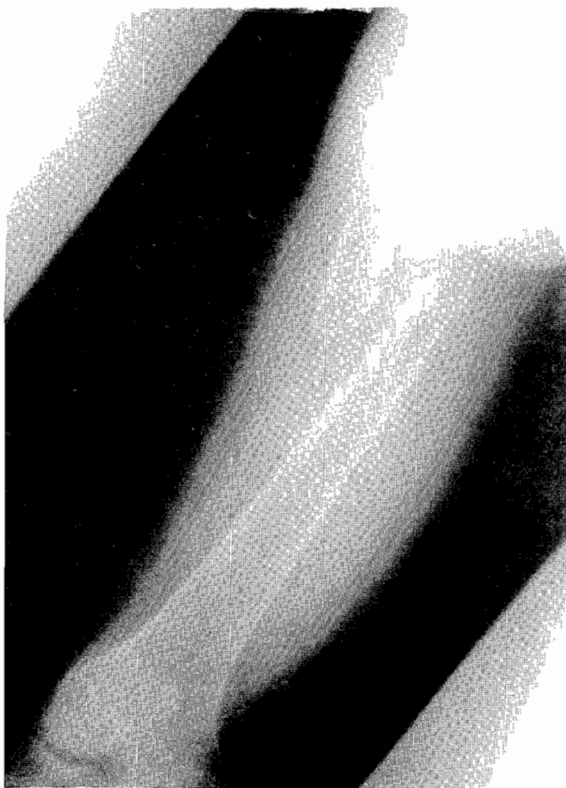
A photo-radiograph (AP view) of the right femur in a 29-year bus driver who developed atrophic non-union with severe disuse osteoporosis after 2 years of treatment at the TBS.
